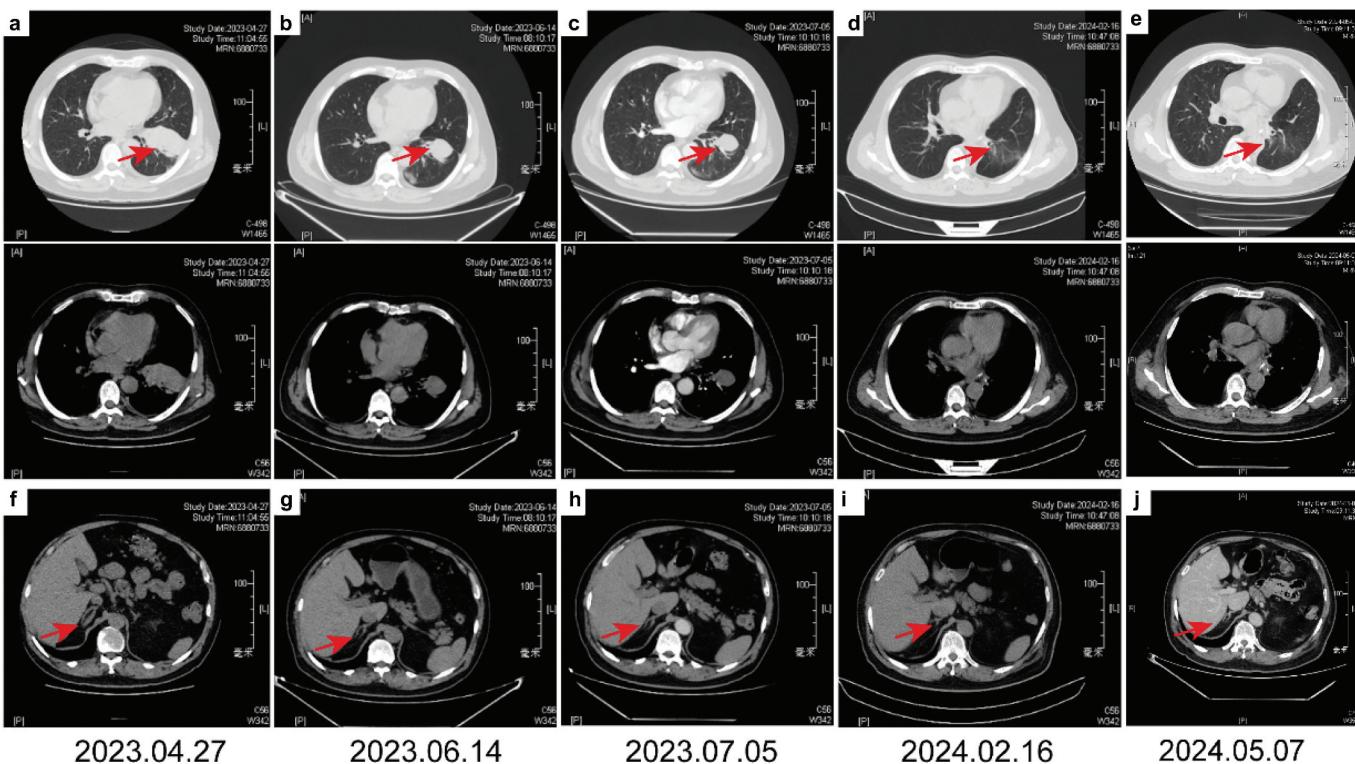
CT scanning of the patient. (a) After the first cycle of conversion therapy. (b) After the second cycle of treatment. (c) Significant decrease in primary tumor mass after the fourth cycle of treatment. (d–e) Post-operative follow-up. (f–h) Corresponding radiographic images of responses of the metastatic lesion in the right adrenal gland, with the presence of metastasis at baseline, and subsequent images showing post-treatment PR, and finally the absence of metastasis (cCR).
